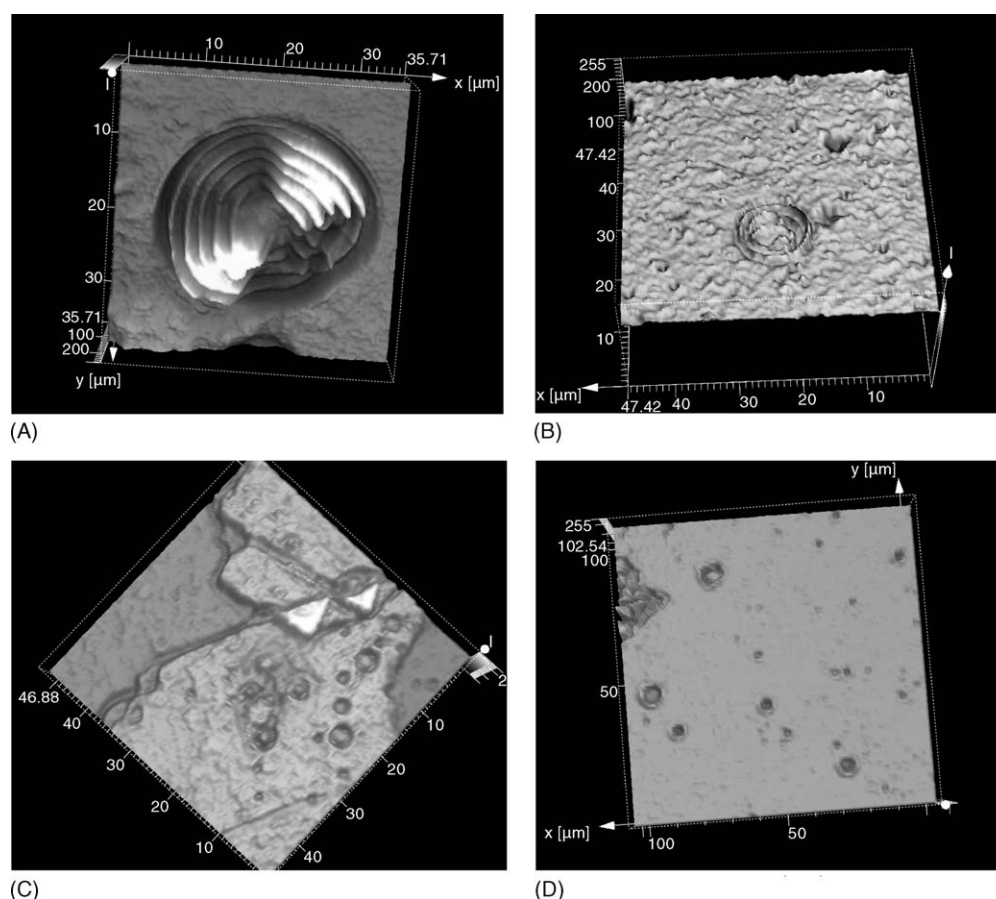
Transmission tridimensional CLSM images of different kinds of liposomes all prepared in the presence of 5 mM ketoprofen–HP $\beta$ Cyd complex: MLV (A), FATMLV (B), LUV (C) and SUV (D).
